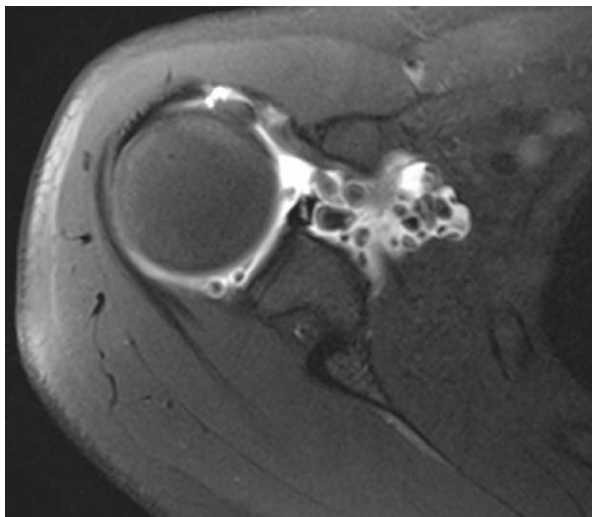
T1-weighted MR arthrogram of the axial section demonstrating multiple loose bodies within the joint space
